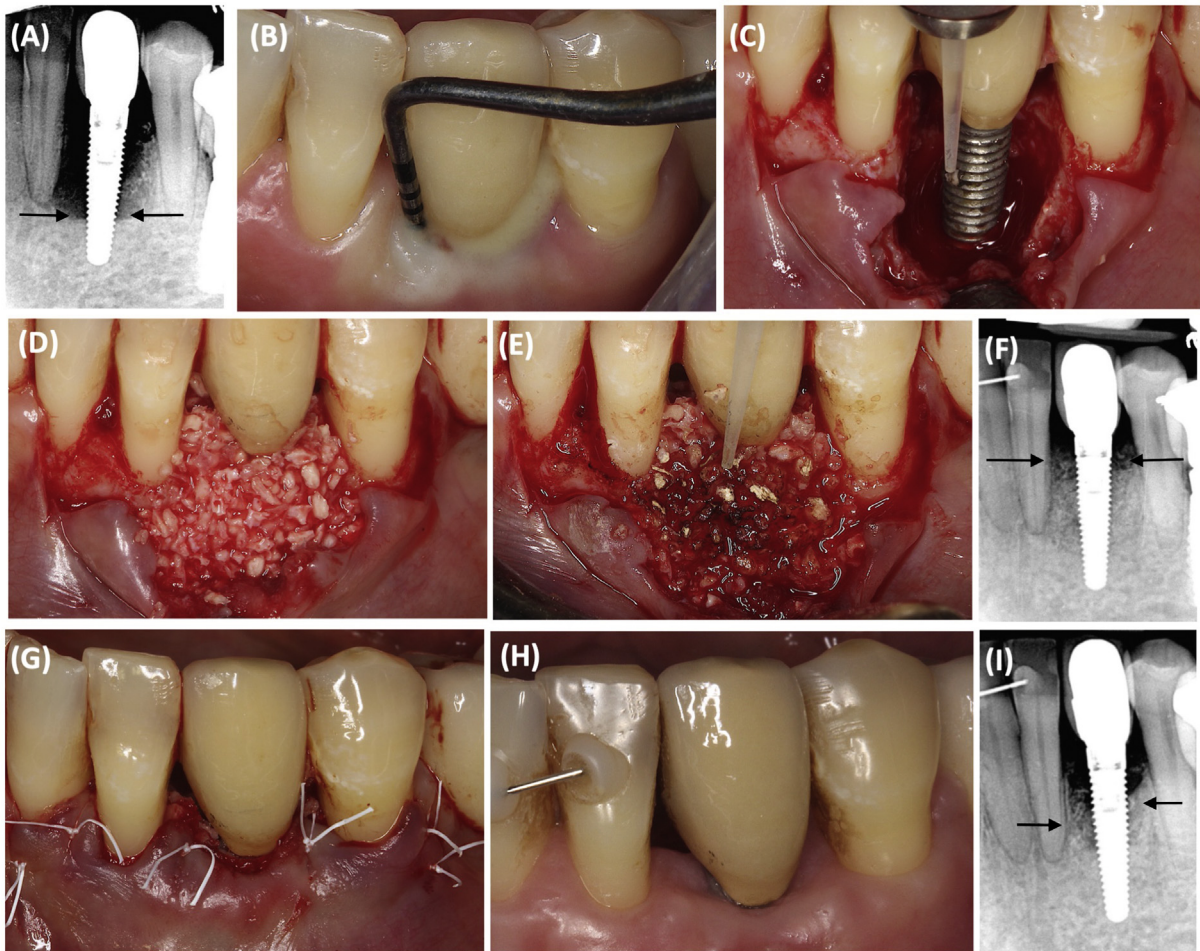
The clinical and radiographic photographs of our case. (A, B) The pocket depth around the #33 implant is 13 mm with bleeding on probing and exudate. Radiographic evaluation revealed a severe circumferential bony defect around the implant. Arrows indicated the bone defect. (C) Following flap elevation, granulation tissue was effectively removed, and implant surface debridement was performed using Er:YAG laser with a water spray. (D) After implant surface debridement by Er:YAG laser, a bone graft mixed with blood was placed into the bony defect and filled up to the crest of implant fixture platform. (E) Instead of using a collagen membrane, Er:YAG laser irradiation without water spray under non-contact mode was employed to stabilize the blood clot and bone graft by inducing thermal blood coagulation. (F) Bone material grafted was examined by radiographic evaluation. Arrows indicated the regenerated bone. (G) Suturing. (H, I) After a two-years follow-up, the soft tissue is favorable, and the pocket reduced to approximately 3 mm around the #33 implant without bleeding on probing, and the radiographic examination showed a favorable bone-like dense tissue around the implant and the original severe bone defect was almost successfully repaired. Arrows indicated the regenerated bone.
